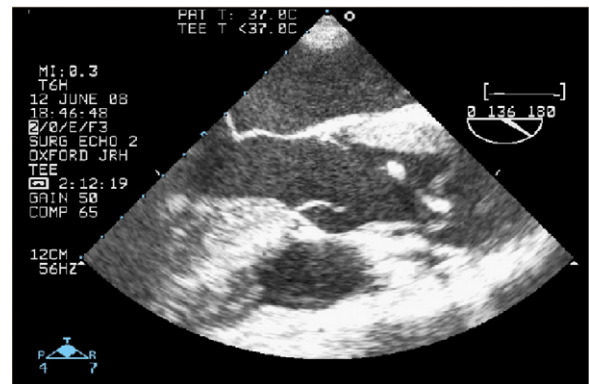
Transesophageal echocardiography long-axis view with dissection flap visible in root and guide catheter in situ.
